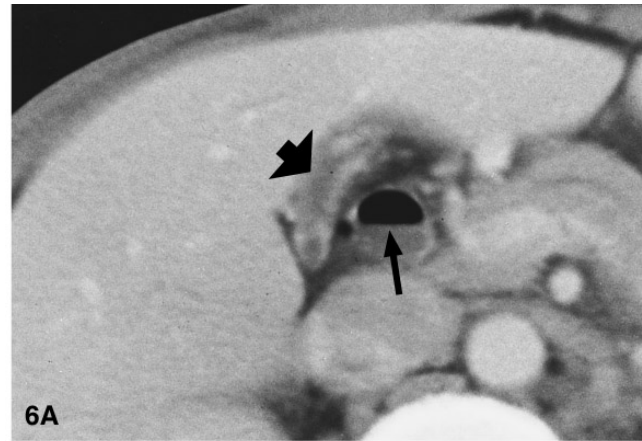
Gallbladder cancer with gas-forming infection. Enhanced CT shows bubbly air collection (arrow) in the enlarged gallbladder. Surgery confirmed that the air collection was detected in the large necrotic polypoid cancer.
